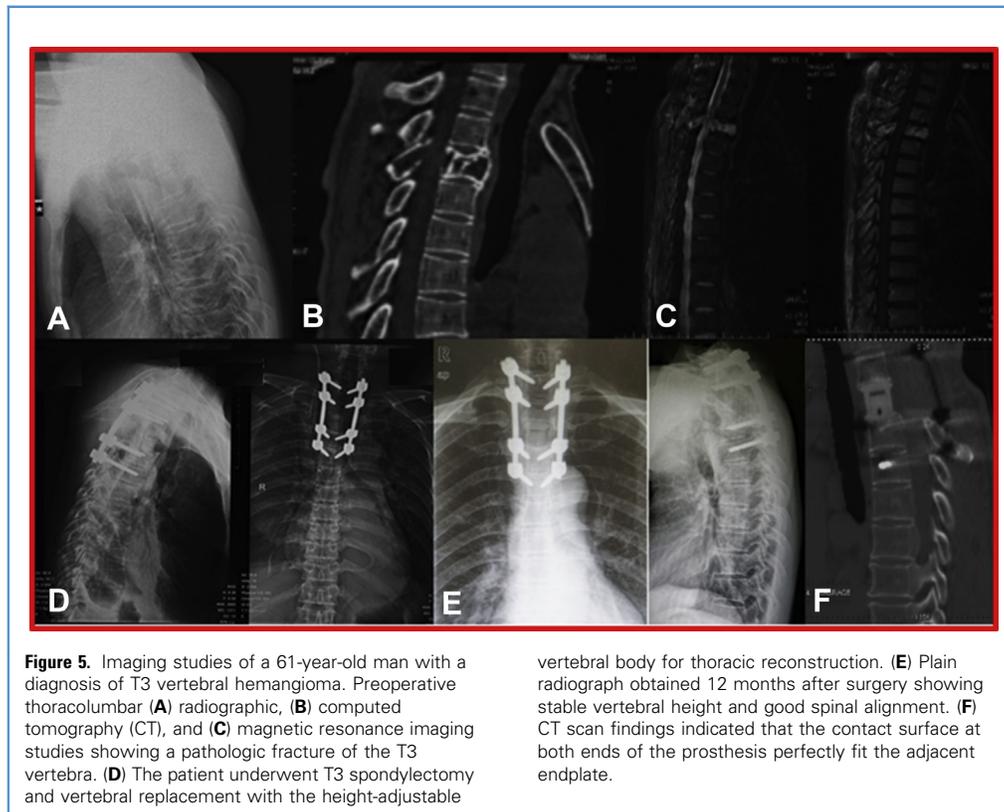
Imaging studies of a 61-year-old man with a diagnosis of T3 vertebral hemangioma. Preoperative thoracolumbar (A) radiographic, (B) computed tomography (CT), and (C) magnetic resonance imaging studies showing a pathologic fracture of the T3 vertebra. (D) The patient underwent T3 spondylectomy and vertebral replacement with the height-adjustable
